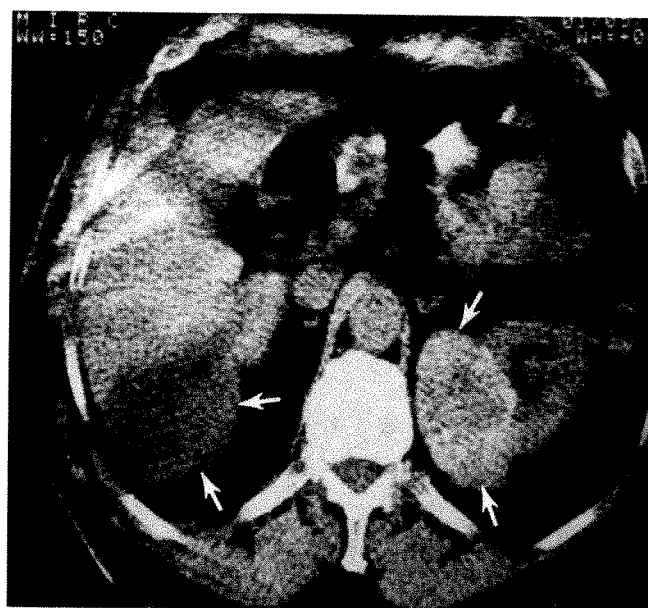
69-year-old man without urinary tract symptoms. Urography demonstrated multiple masses in both kidneys. Because of high location of lesions under rib cage, ultrasonography unsatisfactory despite angling of transducer. Angiography disclosed multiple avascular masses in both kidneys. CT findings: right kidney—low density (arrows; 5 EMI units) oval mass characteristic of benign renal cyst; left kidney—solid density (arrows; 36 EMI units) elliptical mass consistent with neoplasm. CT scans of other masses characteristic of benign cysts.
